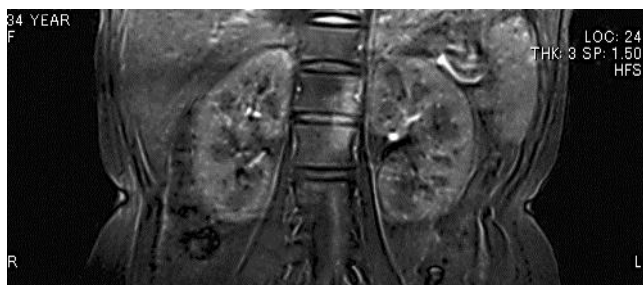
Follow-up MRI taken 3 months after the intervention. No abnormalities, including the dilatation of the renal vein, can be seen.
